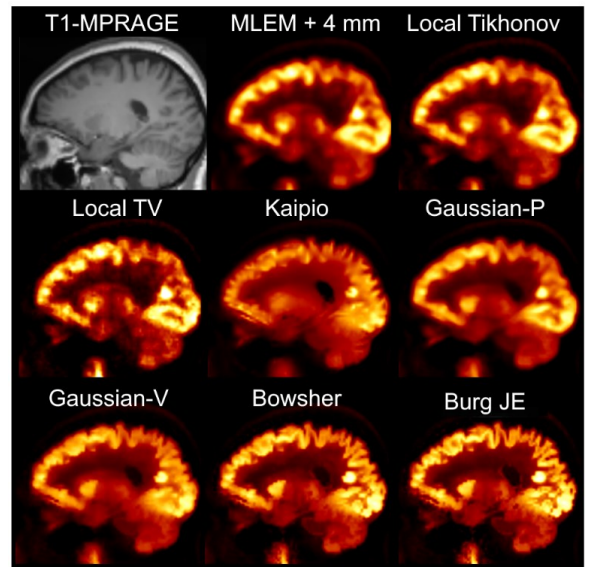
The reconstruction results of the clinical FDG dataset. The activity profiles of the reconstruction methods has been shown for three different regions along the indicated dash lines.
